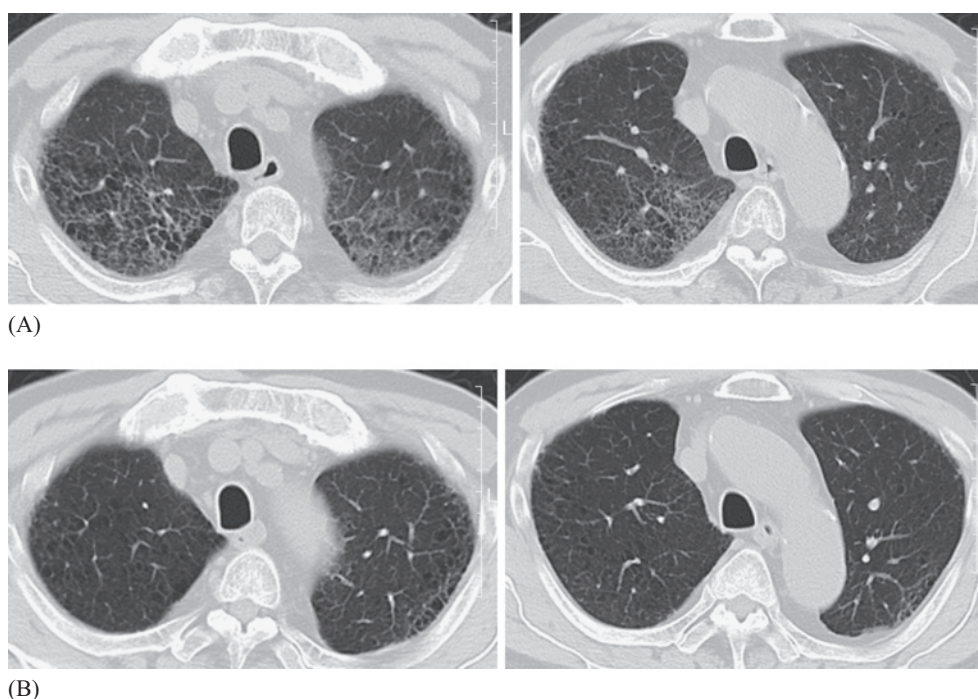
Chest computed tomography scans before (A) and after (B) treatment for lung injury. (A) At onset of clinical acute respiratory distress syndrome, ground glass opacity is present in both lung fields. Background emphysema resulted in a Swiss cheese appearance of lung tissue. (B) At the time of recovery from lung injury, the ground glass opacity has disappeared. There has been no recurrence of lung cancer.
